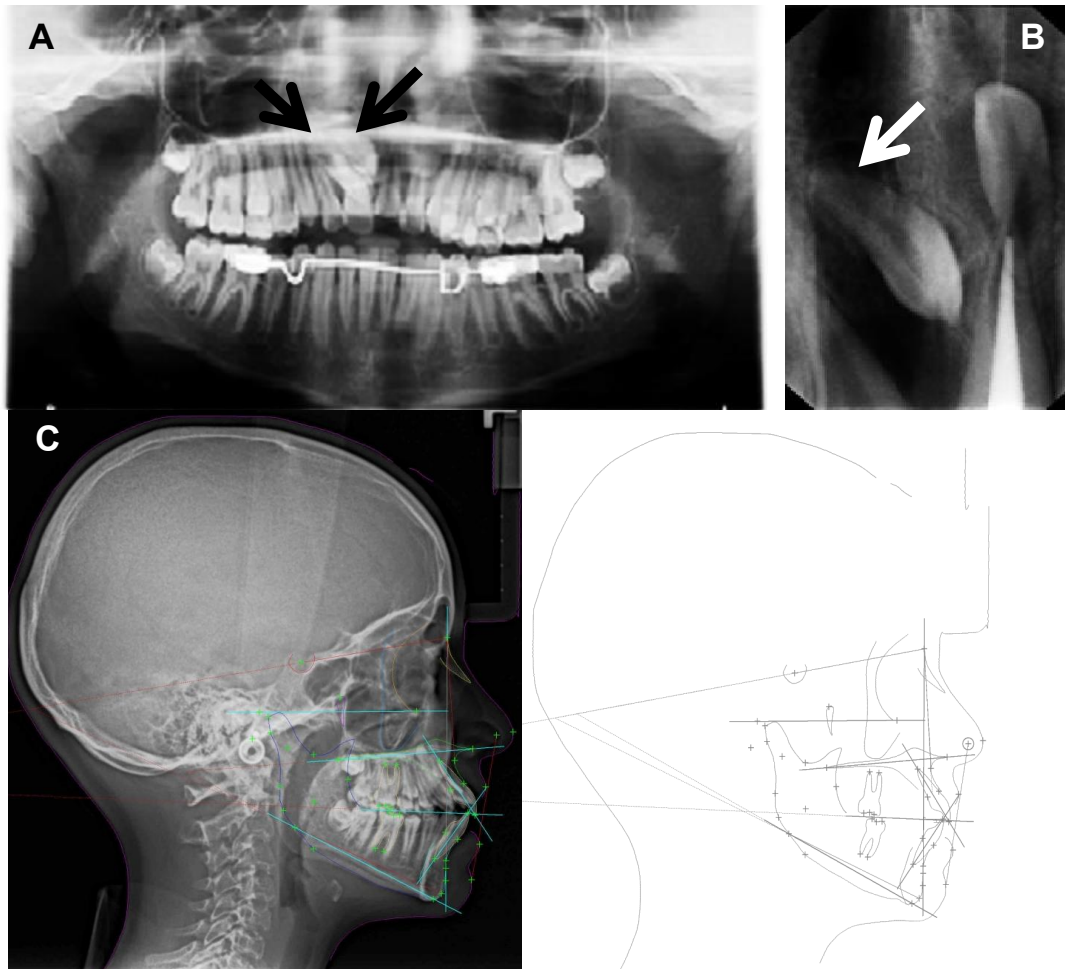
Radiographic examination of the patient; A)- Panoramic view, B)- Periapical view; showing supernumerary mesiodens (arrows); C)- Lateral cephalogram and paper tracing for comparing patient's landmarks and normal cephaometric values
